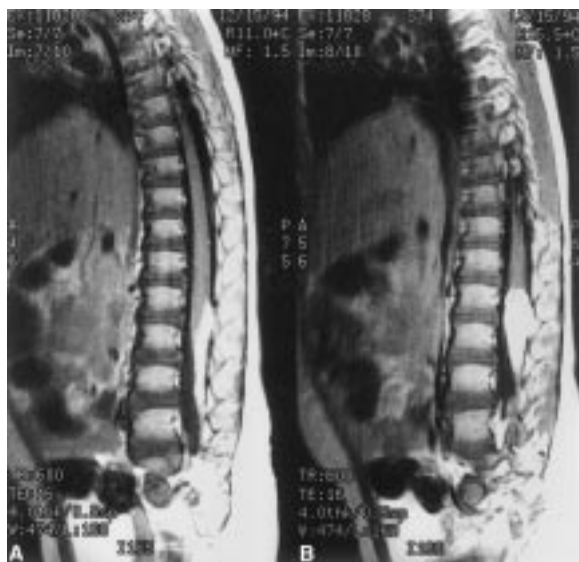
Sagittal, unenhanced T1 weighted MRI images of transitional lipoma with nerve roots coursing through the lipoma.
